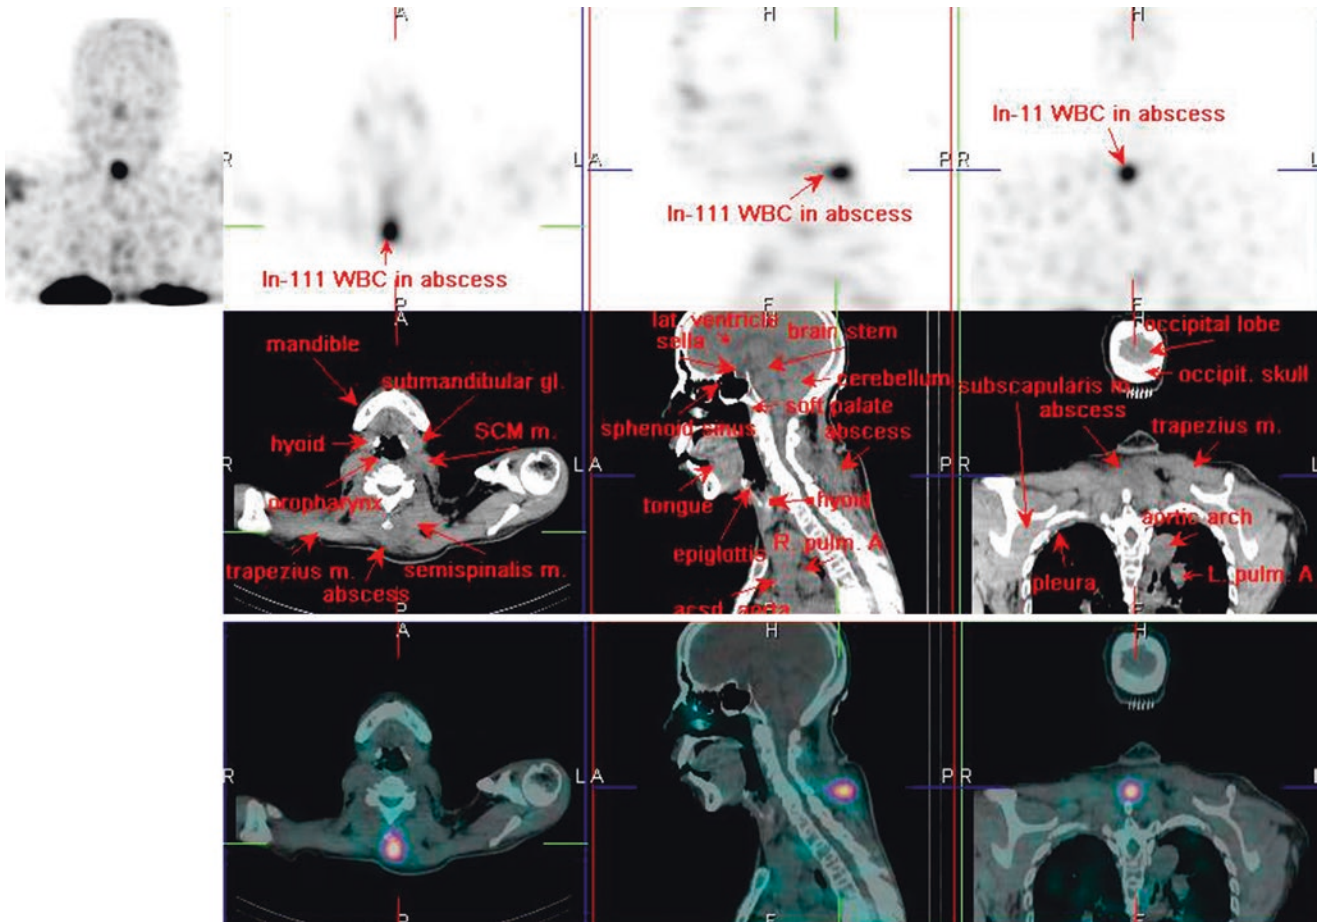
¹¹¹In-WBC SPECT/CT
